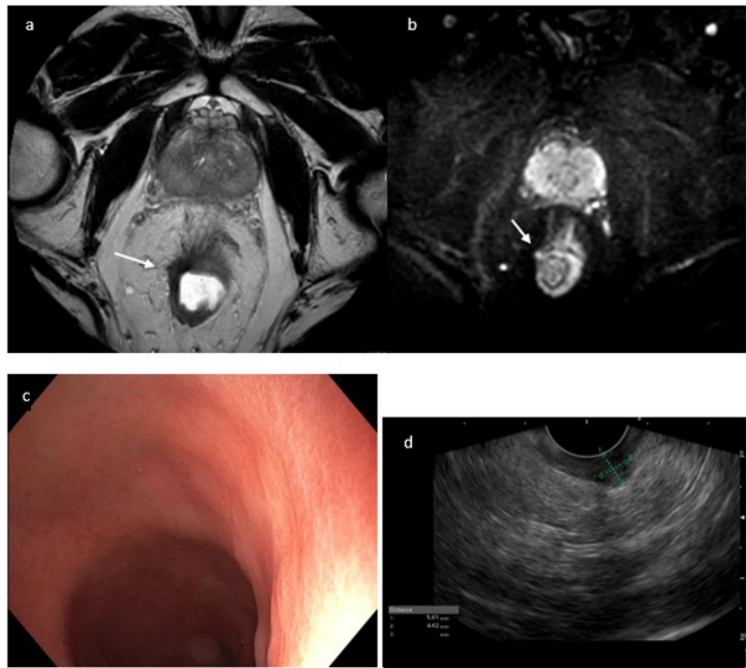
Patient 2. (a) T2 transversal Multicoil MRI image and (b) DWI MRI image from the MRI investigation that identified the submucosal regrowth (white arrows). (c) Echo-endoscopic images taken during (c) the last rectoscopy that confirmed appearance of cCR and (d) the echo-endoscopy performed at the time of detection of a submucosal regrowth on MRI. The echo-endoscopy shows a 5,5 x 4,5 mm hypoechoic alteration in the submucosa that reaches to the muscular layer (green dotted lines). cCR = clinical Complete Response; DWI = Diffusion Weighed Imaging
